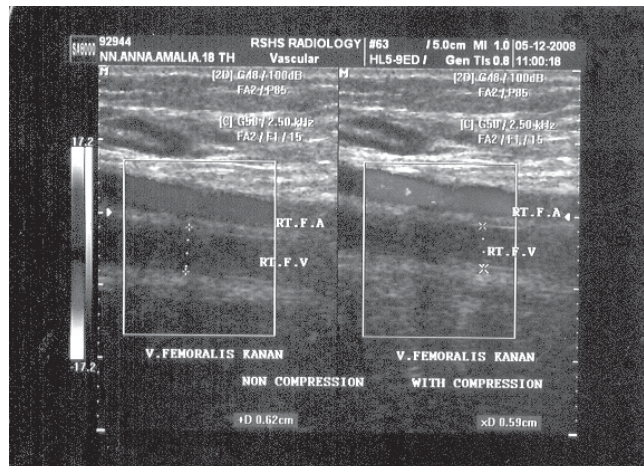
Compression ultrasonography: non compressible right femoral vein
